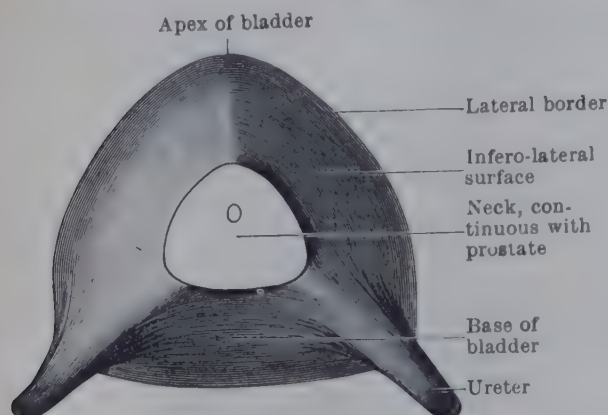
INFERIOR ASPECT OF EMPTY MALE URINARY BLADDER. From a subject in which the viscera had been hardened *in situ*.
